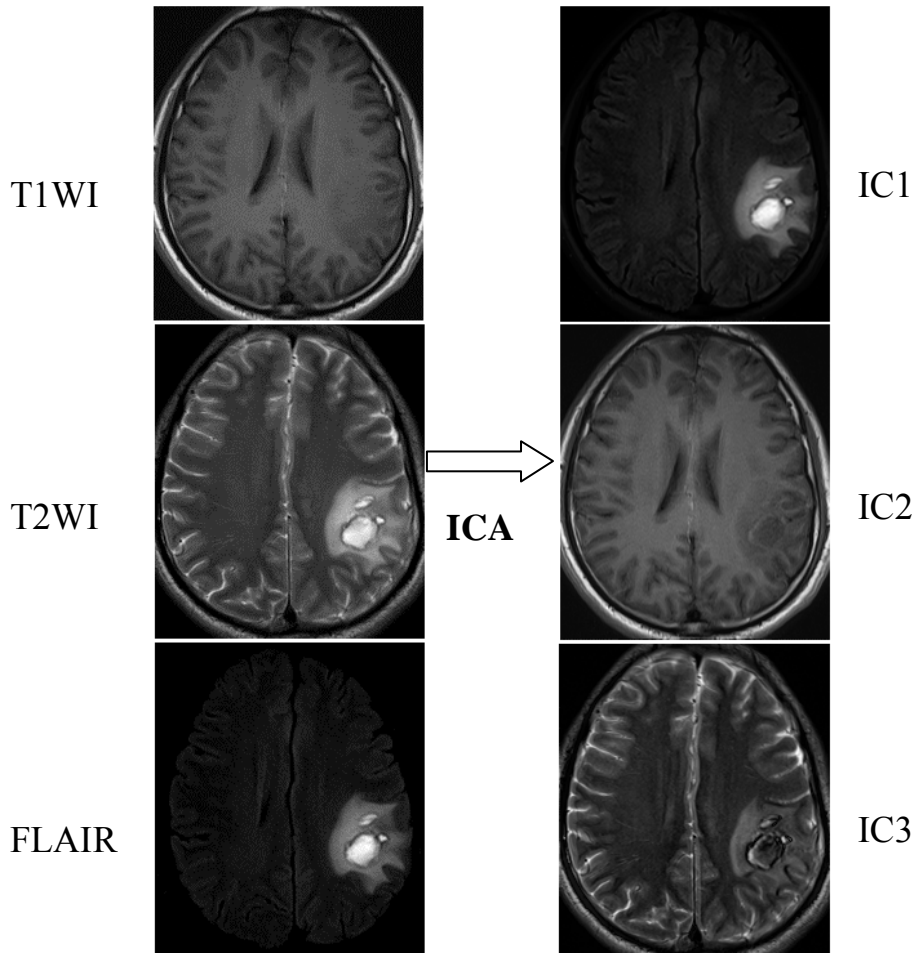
ICA in brain MRI
